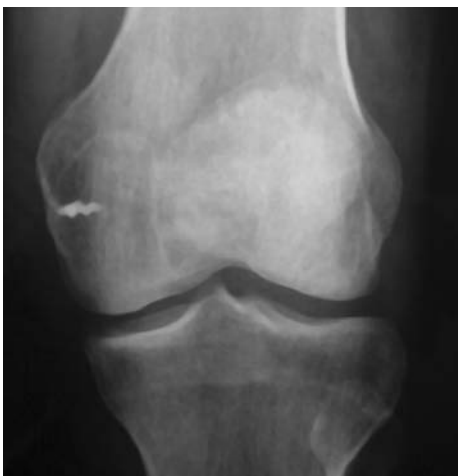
knee radiograph in frontal plane showing inserted anchor at the medial epicondyle for mpfl insertion.
